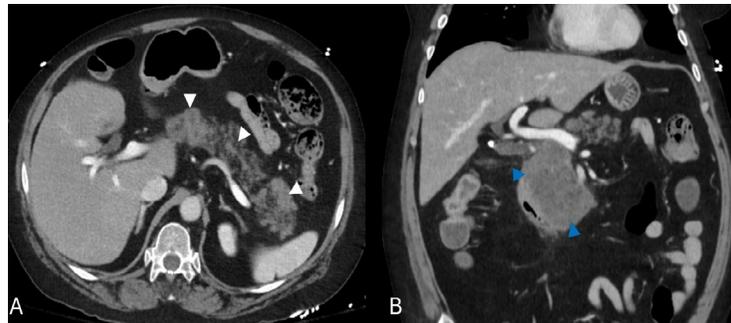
Computed tomography (CT) of the abdomen and pelvis with contrast. (A) Axial image demonstrates diffuse stranding and edema throughout the pancreatic body and tail (white arrowheads). (B) Coronal reformatted image shows stranding with mass-like thickening of the pancreatic head (blue arrowheads). Attenuation of the inflamed tissue appears similar to that of normal pancreatic parenchyma.
